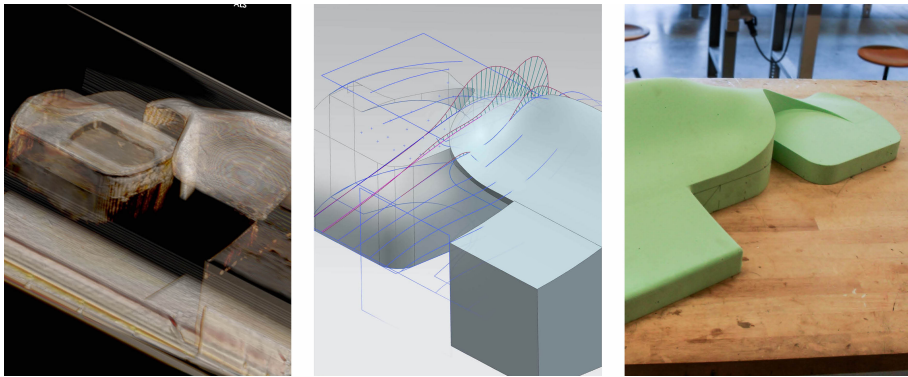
Digitising process of BCI-L. Left: Generated 3D point cloud through CT scanning BCI-L; Middle: Surface modelling and optimising support surface in a CAD-CAM environment; Right: Mirrored, CNC-milled high density PU foam prototype.
